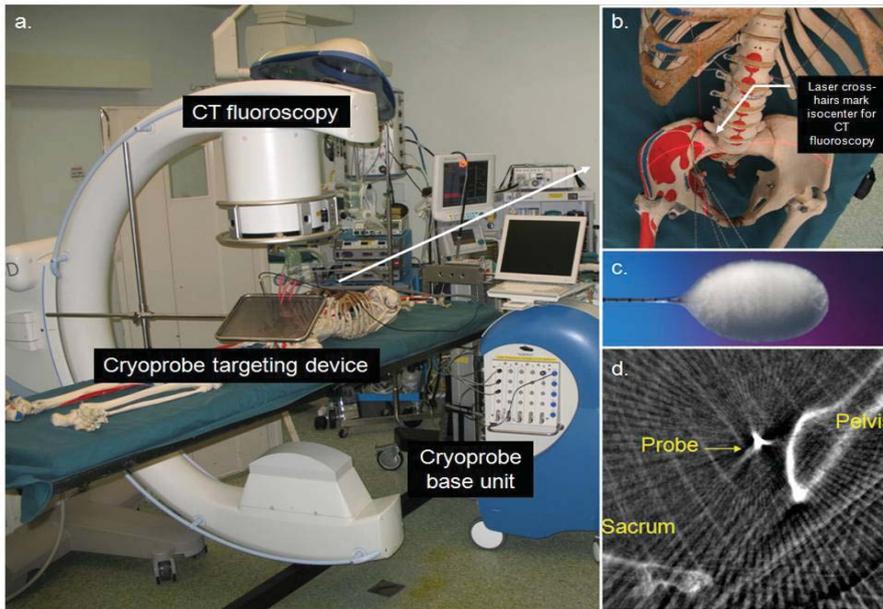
(a). CT fluoroscopy, Cryoprobe targeting device and base unit. Fig. 1(b). Cryoprobe zone of ablation. Fig. 1(c). Cryoprobe. Fig. 1(d). Fluoroscopy picture of probe in position within the pelvis.
